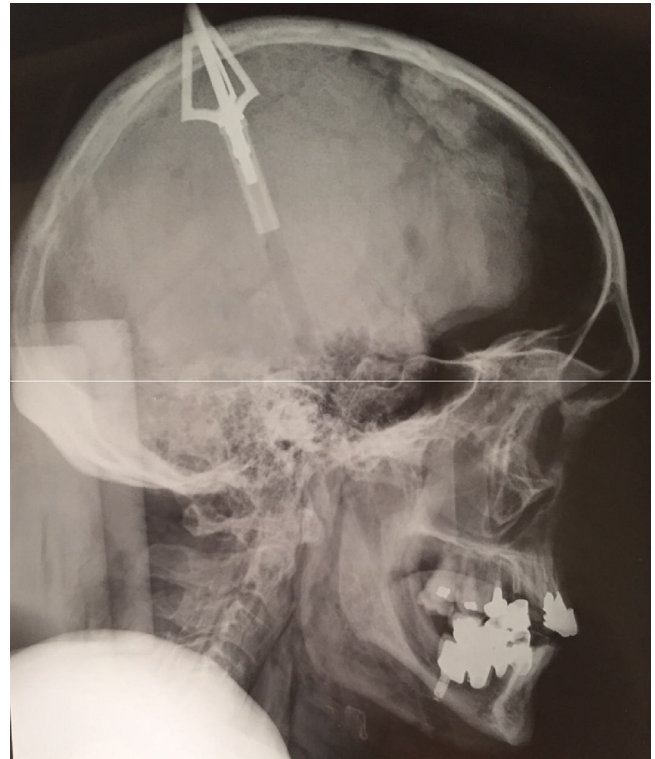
X-ray showing the three-bladed arrow stuck in the skull.
